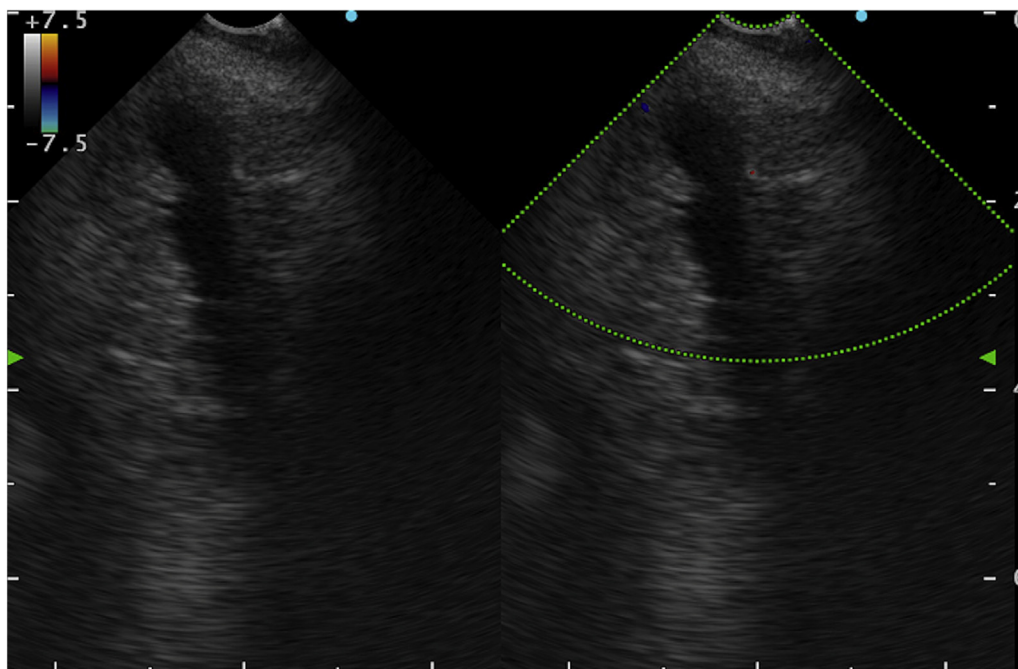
EUS reveals the dilated main pancreatic duct and its position with an absence of interposed blood vessels on color Doppler imaging.
